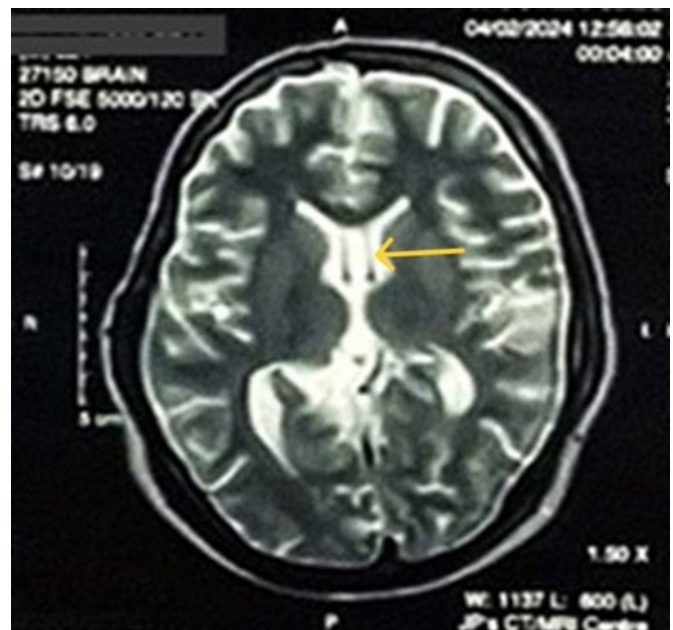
T2 weighted MRI images done at 22 years of age showing CSP cyst (arrow) and its posterior extension.
